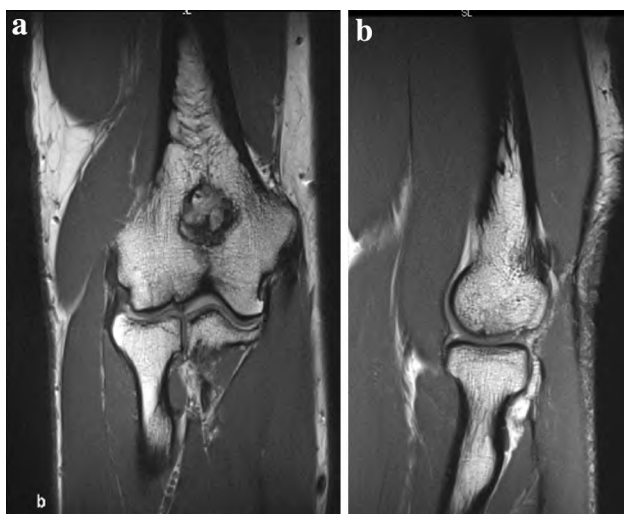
Postoperative a T1 coronal and b T1 sagittal MRI scans of patient 7 (7.4 years postoperative), showing a vital and congruent osteochondral cylinder
